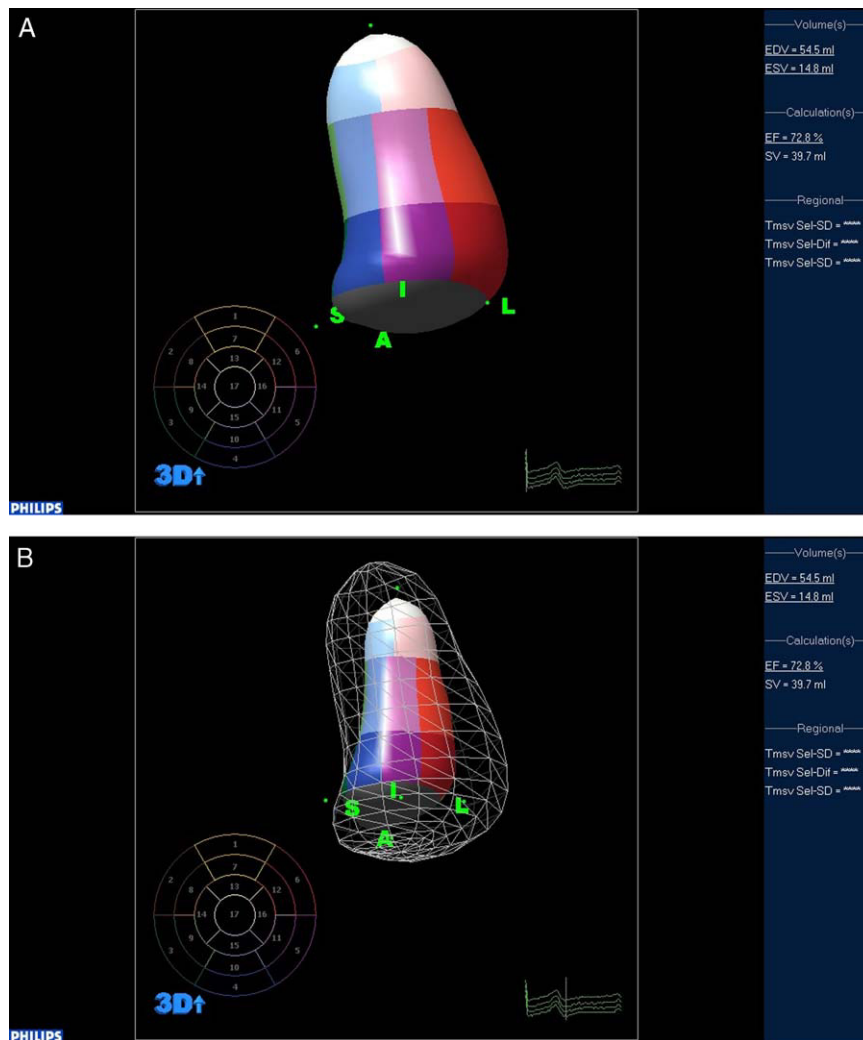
Calculation of left ventricular volumes and ejection fraction using three-dimensional echocardiography. A: End diastolic frame. B: End systolic frame.
